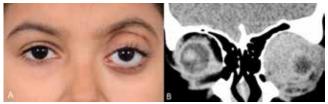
(A) Left proptosis (B) Coronal CT with non-homogenous diffuse isodense lesion in the left orbit which on biopsy proved to be Wegener's granulomatosis.
